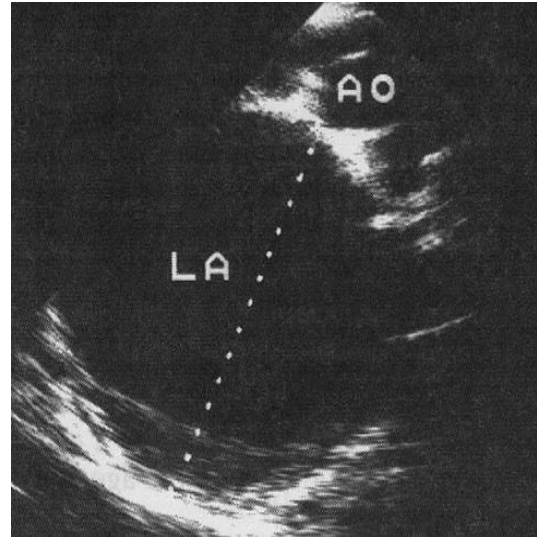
Echocardiographic imaging of the patient showing marked left heart dilatation
